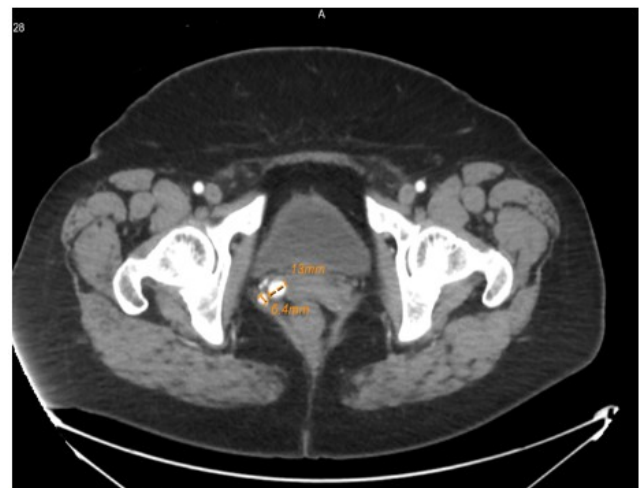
Figure SEQ Figure * ARABIC 2 - Contrast-Enhanced CT in an axial plane: At the right vaginal wall is a vascular structure, with arterial supply from the vaginal branch of the R-internal iliac artery, and with a vaginal branch draining vein of the R-internal iliac vein.
